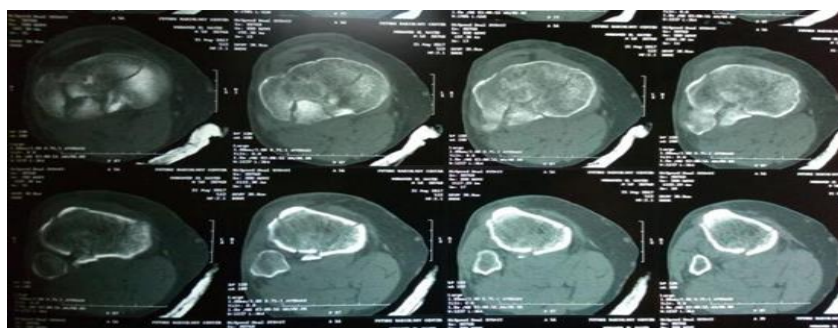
preoperative CT axial cut.
